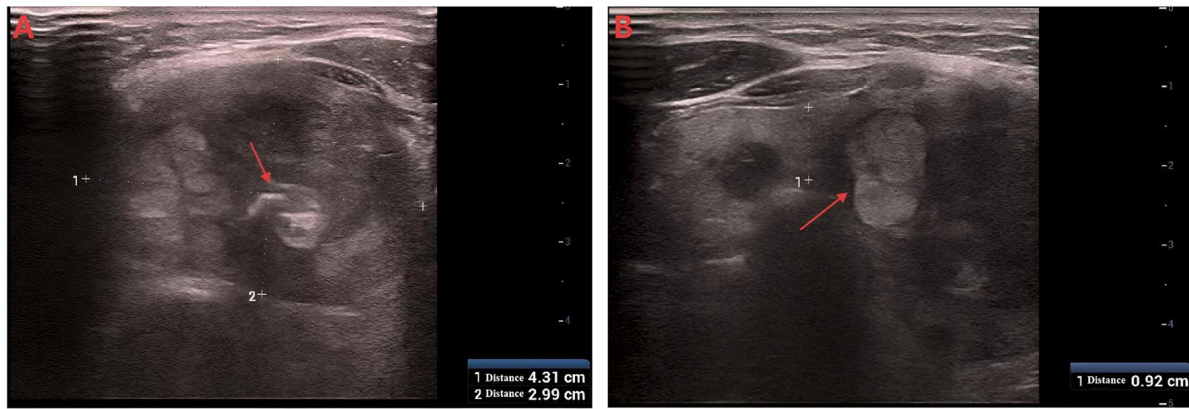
Ultrasound showing multiple bilateral thyroid lobes (Chinese Thyroid Imaging Reporting and Data System grade 3). The ultrasound examination was performed using a Resona 8S system with an L14-5WU transducer. The red arrow indicates the location of the thyroid mass. Multiple cystic-solid nodules in both lobes, demonstrating well-defined borders and regular morphology. A: The largest nodule in the left thyroid lobe measures approximately 4.3x3.0x4.0 cm. B: The largest nodule in the right thyroid lobe measures approximately 1.4x0.9x1.4 cm. CDFI (Color Doppler Flow Imaging): Linear blood flow signals are detected within and around the nodules. The echogenicity of the remaining parenchyma appears relatively uniform.
